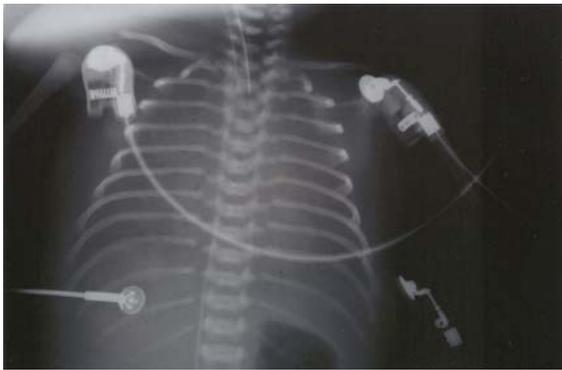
Preoperative X-ray depicting diffuse pulmonary edema to such extent that cardiac shadow is lost.
